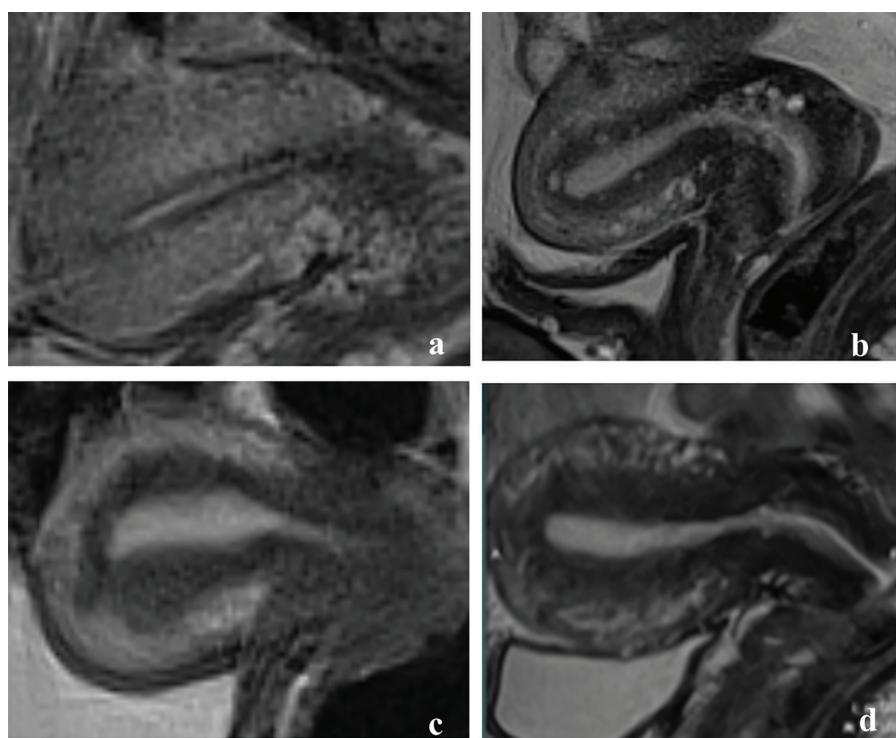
JZ-MRI ReproClass B subtle changes: hypotrophic JZ (a), Normal JZ with microcystic changes (b), Focal thickened JZ (c), Enlarged JZ occupying less than two-thirds of the total myometrial thickness (d). JZ-MRI: junctional zone- magnetic resonance imaging.
